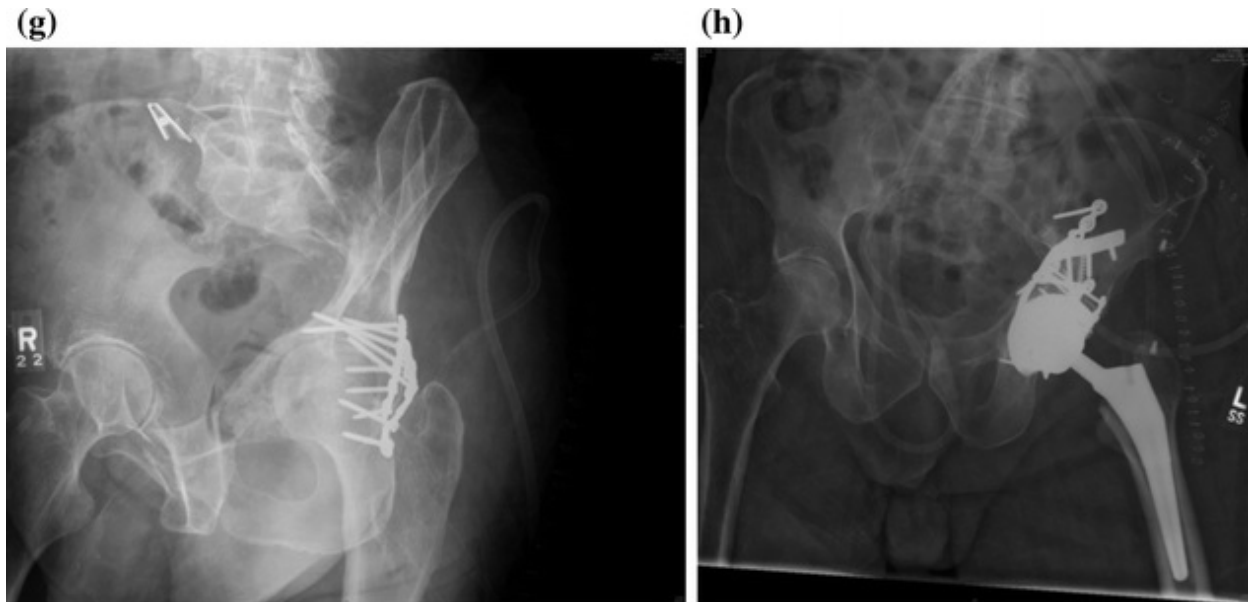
a–c Anteroposterior (AP) obturator oblique and iliac oblique X-ray, respectively, following a fall from a standing position. d Axial CT showing the medial dome impaction and central migration of the head. e Coronal CT reconstruction showing the medial dome impaction and central migration of the head. f, g AP and obturator oblique X-ray, respectively, showing the medial subluxation of the femoral head due to a nonunion. h Postoperative AP X-ray after repair of nonunion and arthroplasty
